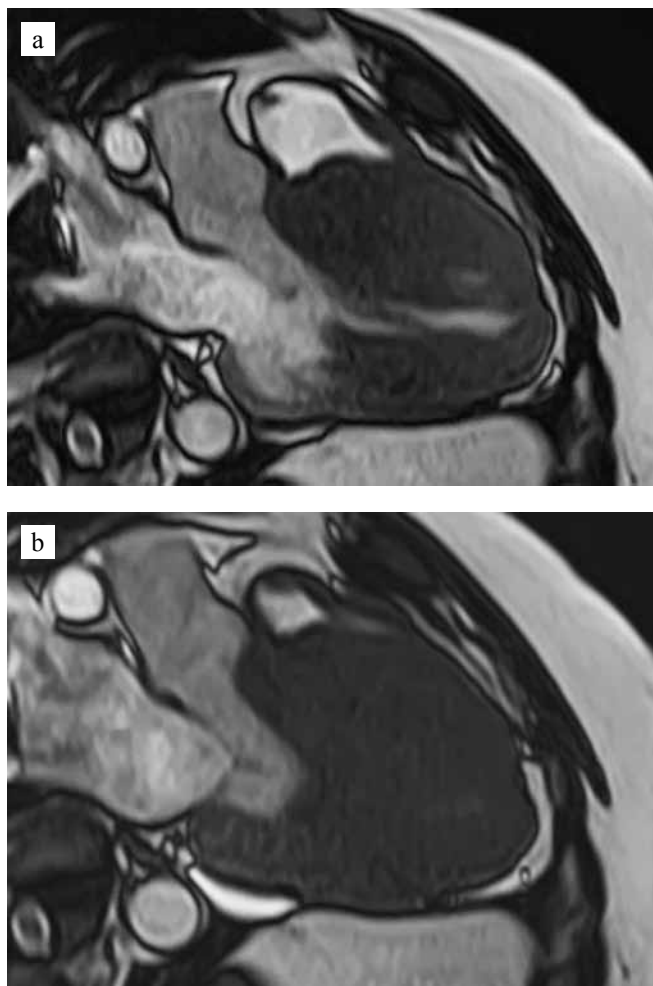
Contrast-enhanced cardiac MRI. a, diastole; b, systole
